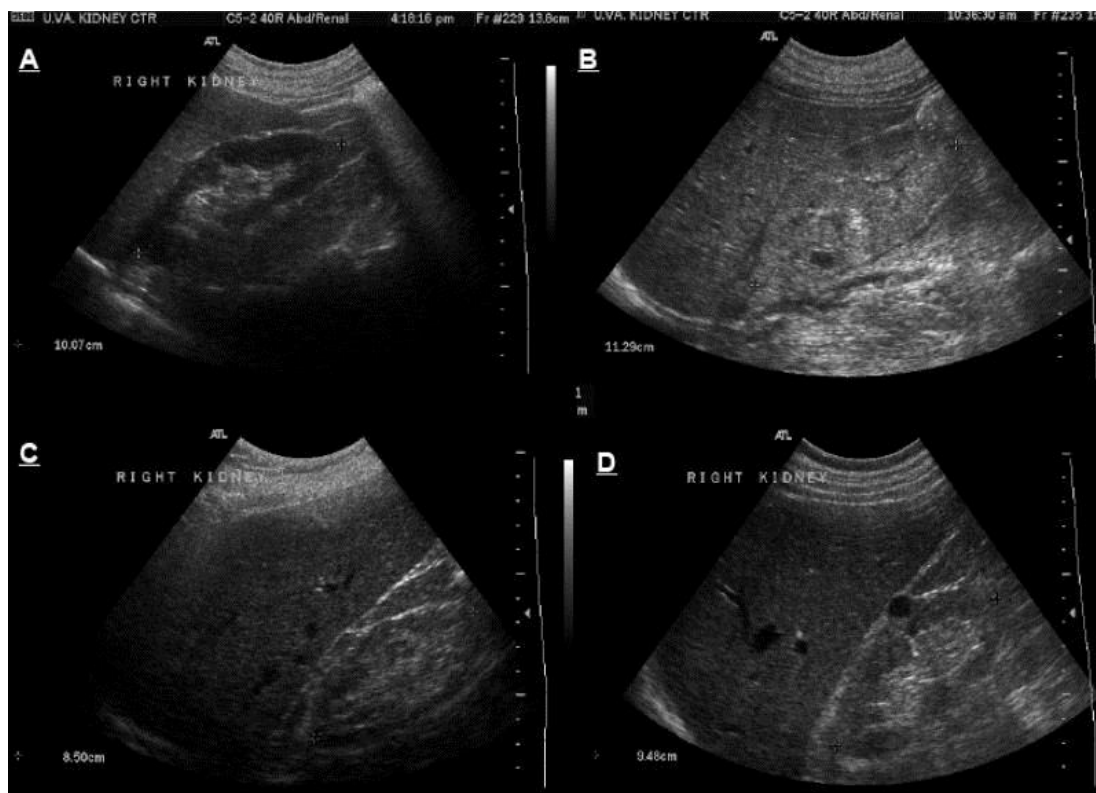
Ultrasonography of the kidney. (A) normal kidney, (B) enlarged and echogenic kidney with loss of differentiation between cortical, medullary and sinus fat compartments in a case with acute kidney injury, (C) small, slightly echogenic kidney with thin cortex in a patient with chronic kidney disease and (D) normal size but echogenic kidney with a single simple cyst in a patient with chronic kidney disease secondary to diabetic nephropathy. [47]
